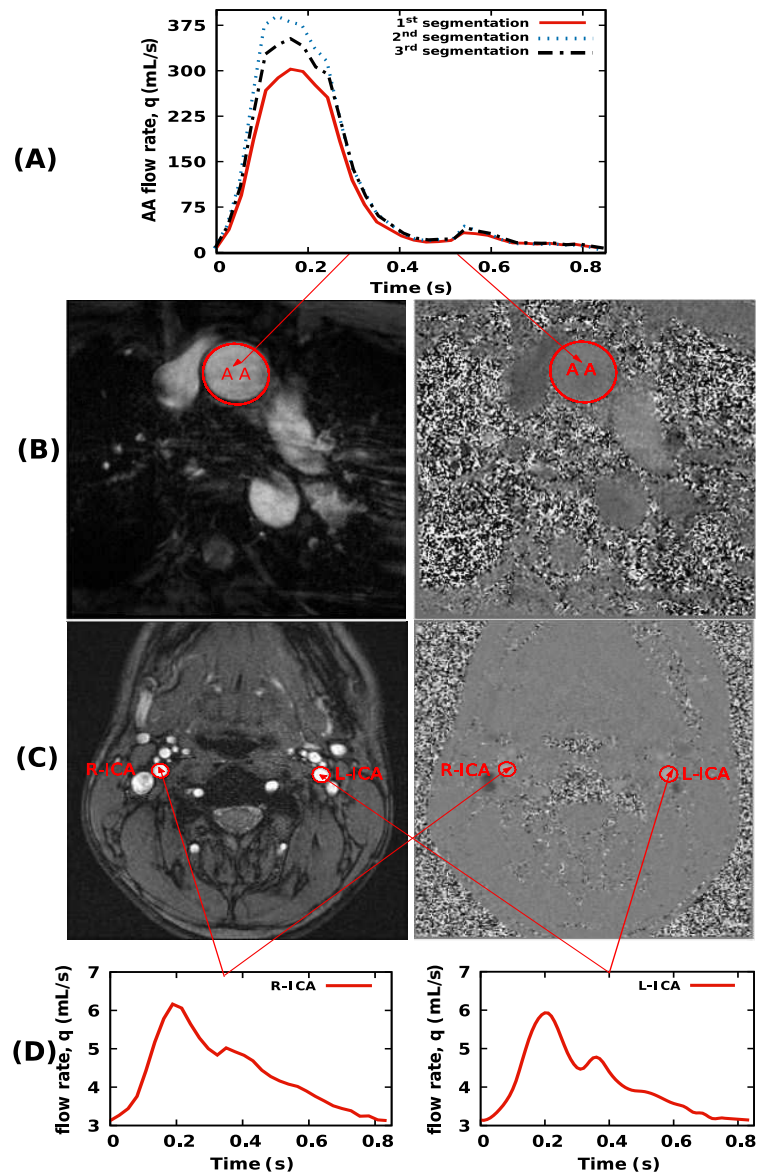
PC-MRI of the patient-specific ascending aorta and internal carotid arteries (right and left) showing the blood flow through one of the selected slices. In the center, on the left are the magnitude images and on the right are the phase contrast images B, and C, with Venc setting of 200 and 80 cm s^{-1} for the ascending aorta and the internal carotid arteries, respectively. The instantaneous blood flow rate values, $q(t)$ are acquired at each time frame and are plotted against time for one cardiac cycle as shown on the top for AA A, and at the bottom for ICAs D. In panel A, the signals obtained from three different segmentations performed by the same “operator” are reported to give a feeling of the uncertainty on the inlet flow rate.
